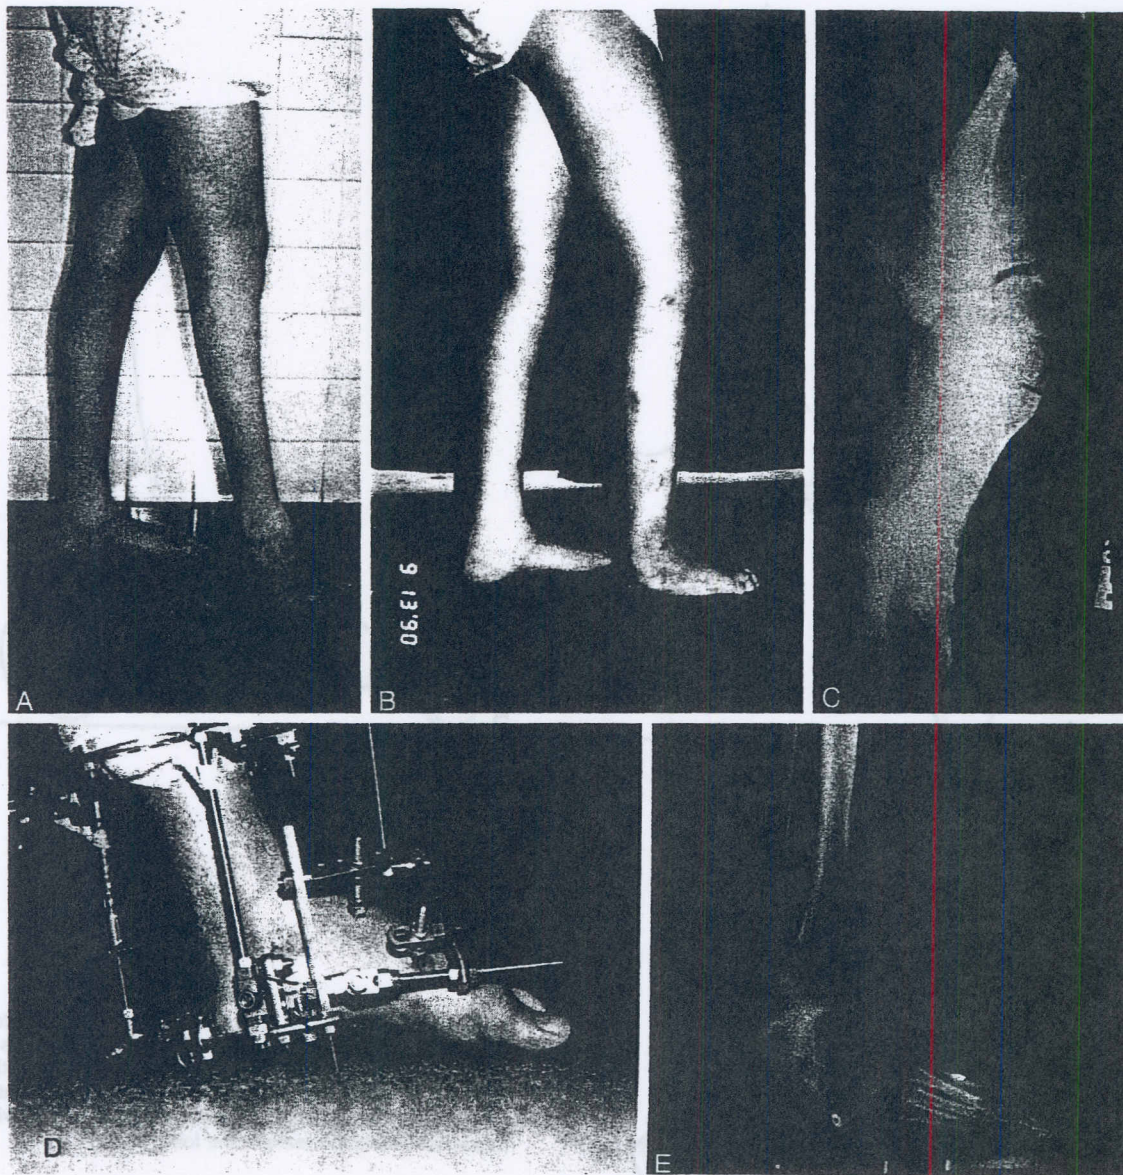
(A), A 16-year-old girl with a fixed equinovarus deformity of the hindfoot and forefoot cavus and adductus due to a clubfoot deformity. (B), After correction of the hindfoot by a supramalleolar osteotomy and nonosteotomy distraction of the forefoot cavus. (C), Preoperative lateral radiograph of the foot demonstrating 65 degrees of equinus. There had been a previous talectomy and tibial calcaneal fusion. Note the forefoot cavus and the short heel. (D), The lateral view of the apparatus is shown. The hinge lies below the level of the osteotomy so as to create a translation effect. (E), After correction, the heel is more prominent because the foot was translated posteriorly. A 2.5-cm lengthening was performed through the distal tibia. With the use of a translation hinge, the regenerated new bone was translated back. Note that the forefoot equinus is eliminated. This was carried out by distraction through the joint and soft tissues. The leg was also simultaneously widened for cosmesis. (Courtesy of Dror Paley, M.D.)
